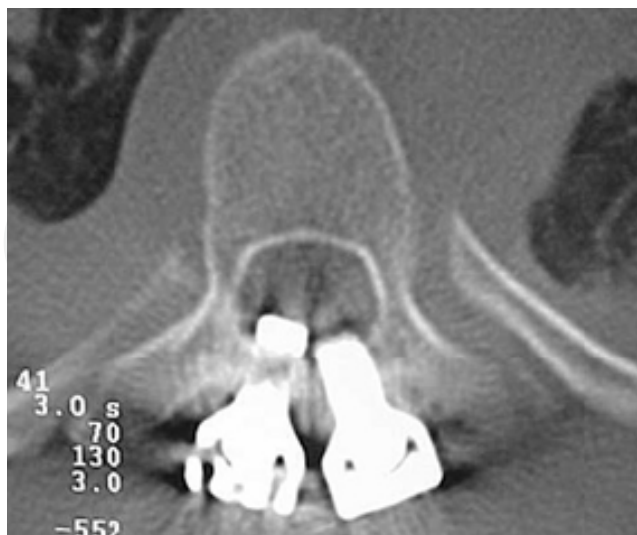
CT Scan showing the intimate connection between sublaminar hooks and the spinal cord.
